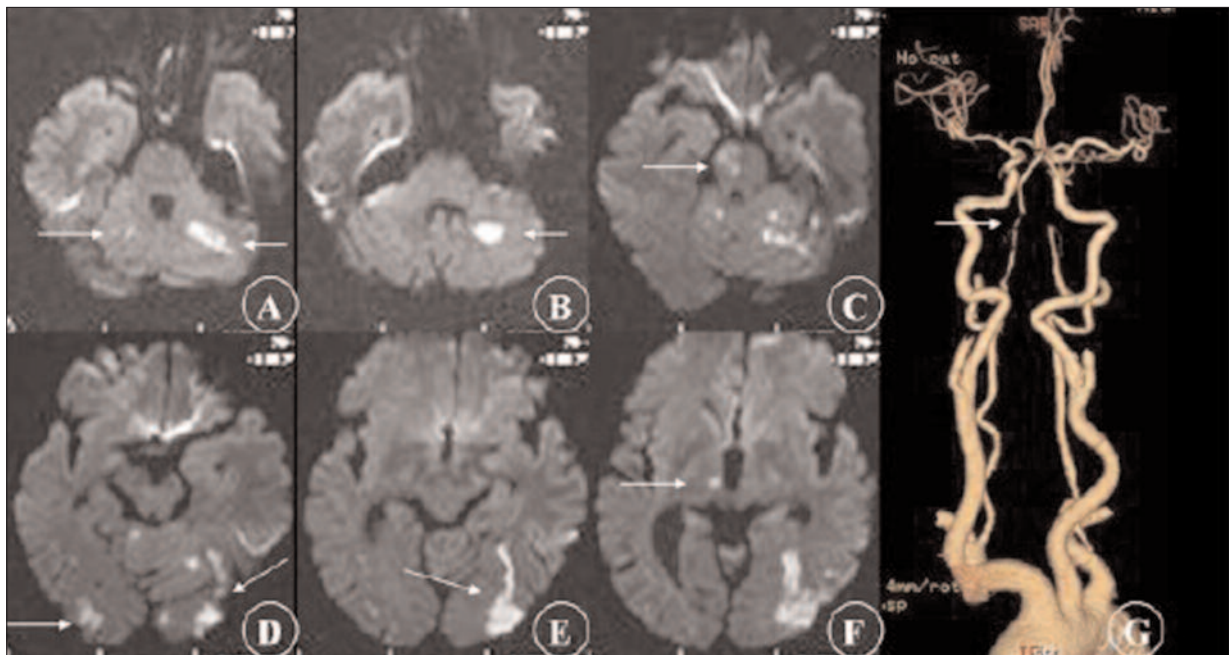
The arrows in A, B, shows the BCI; C, D, E, F, arrows are right pons, bilateral occipital lobes, and right thalamus infarct merged outside the cerebellum; G is CTA map, and the arrows refer to the V4 segment of the vertebral artery and the BA beginning part of narrow occlusion.
